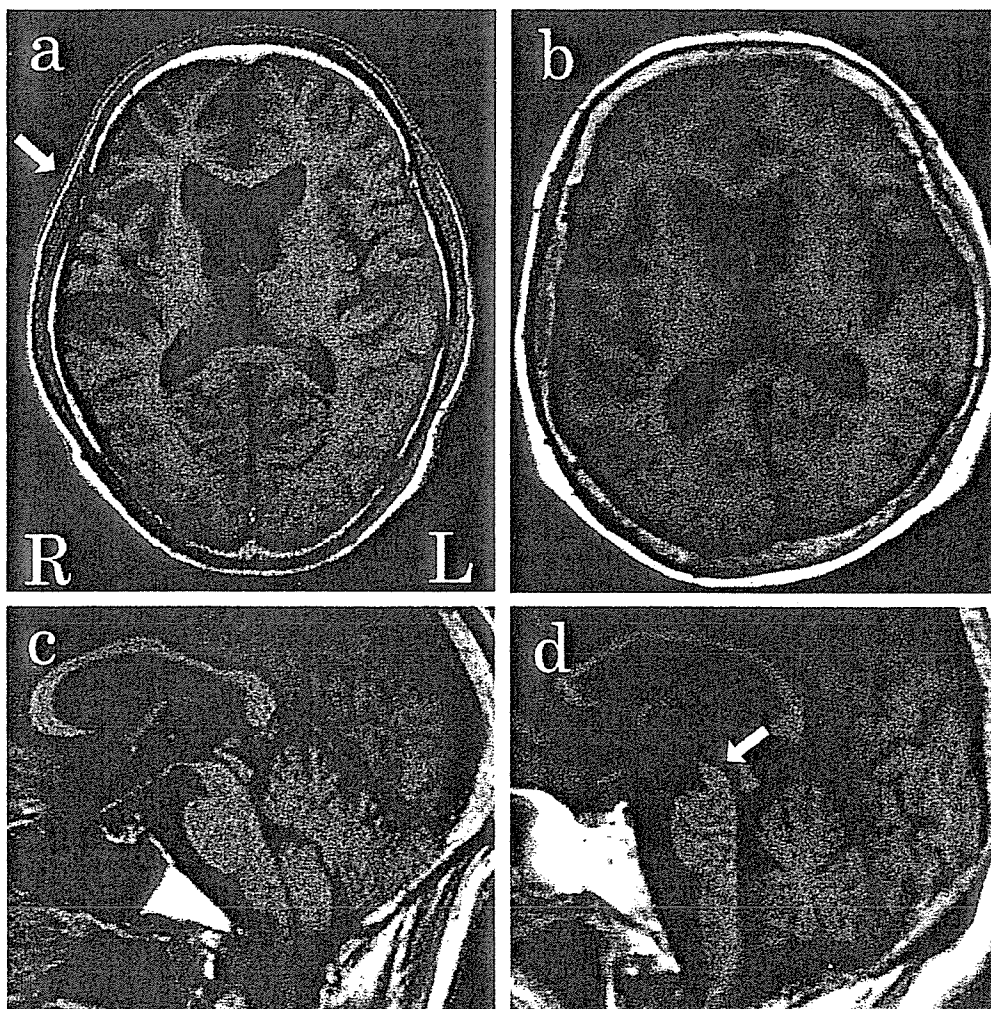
Magnetic resonance imaging (MRI) images on a T1-weighted sequence (TR 500, TE 14) with axial views (a, b) and sagittal views (c, d). The axial MRI shows marked cerebral cortical atrophy that is more pronounced in the right fronto-temporal lobe (arrow) in case 8 with CBD (a, arrow), whereas no asymmetry is seen in case 11 with PSP (b). The sagittal view reveals marked atrophy of the midbrain (arrow) in case 11 with PSP (d), but not in case 8 with CBD (c).
